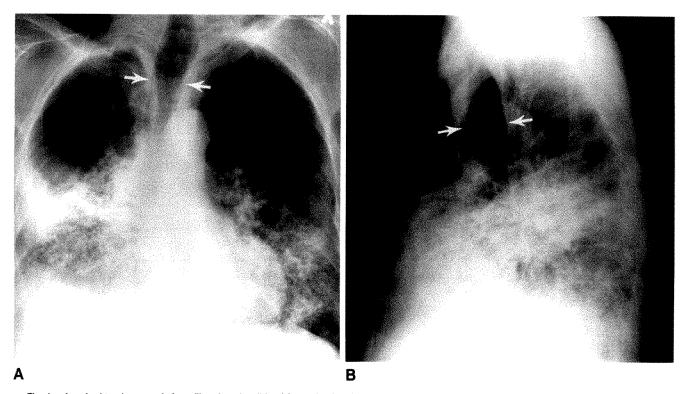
Acquired tracheomegaly from fibrosing alveolitis of 6 months duration causing severe restrictive lung disease in a 64-year-old man. A, On posteroanterior radiograph, transverse internal diameter of trachea 2 cm above aortic arch is 28 mm (arrows), confirming tracheomegaly. B, On lateral view, sagittal diameter is 32 mm (arrows) and anterior wall shows numerous outpouchings that contribute to mucus stagnation and superimposed infection.
